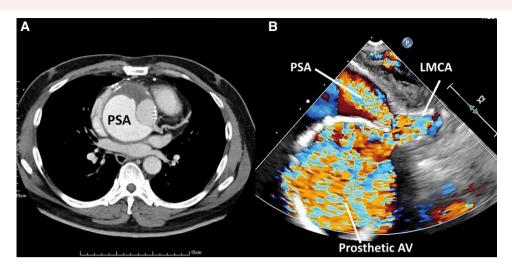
Pre-procedural multimodal imaging analysis. (A) Chest computed tomography revealed an 8.8 × 6.4 cm aortic root pseudoaneurysm, with partial mural thrombus. (B) Transoesophageal echocardiography with colour Doppler confirmed the relationship between the entry point of the pseudoaneurysm and the position of the left main coronary artery. AV, aortic valve; LMCA, left main coronary artery; PSA, pseudoaneurysm.
